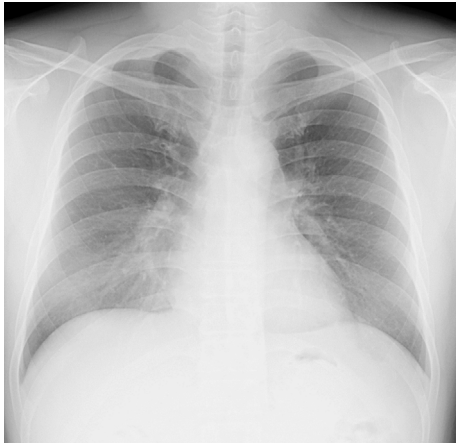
A chest radiograph at the time of the first admission showed the presence of diffuse ground-glass opacity in the bilateral lung fields.
